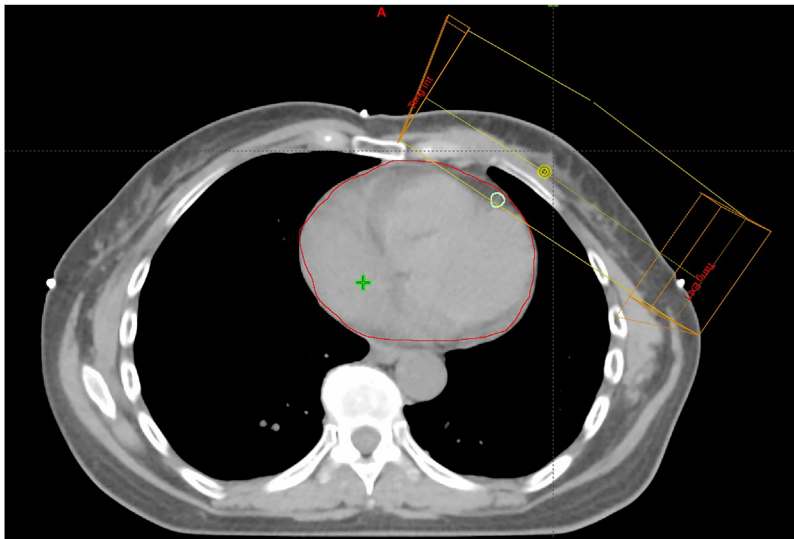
Transversal CT slice showing contoured LAD inside the tangential radiation fields.
